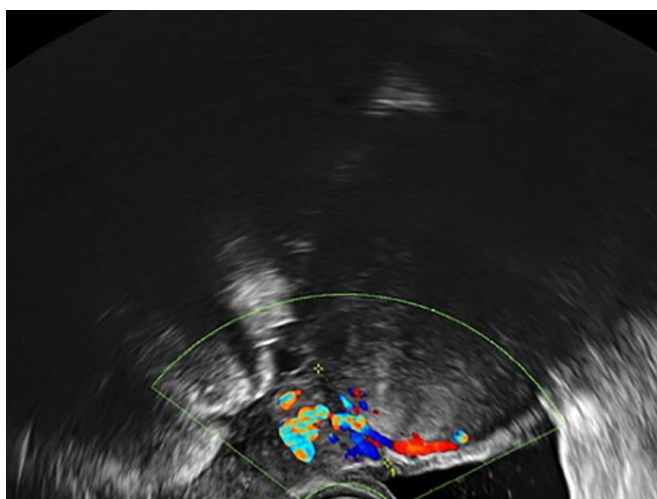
Ultrasound image: the tumor is situated near the uterus
